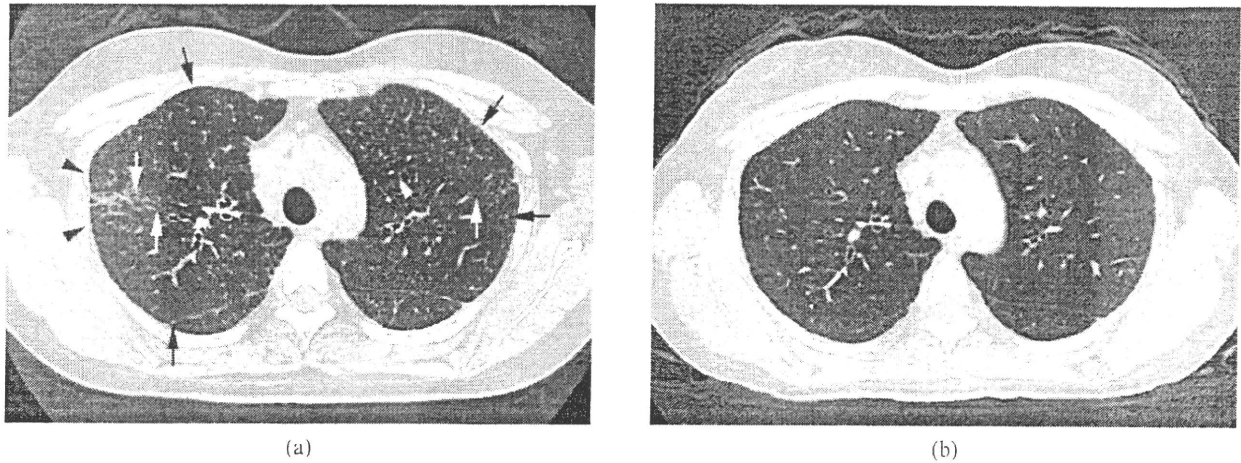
Images in a 35-year-old woman. (a) Transverse CT scan (1 mm section thickness) obtained at the level of upper lobes shows multiple small nodules (arrows) and architectural distortion (arrowheads; KL-6, 1000 U ml⁻¹). Traction bronchiectasis and bronchial wall thickening are also present (white arrows). (b) Transverse CT scan (1 mm section thickness) obtained 6 months later demonstrates disappearance of nodules, architectural distortion, traction bronchiectasis and bronchial wall thickening (KL-6, 285 U ml⁻¹).
